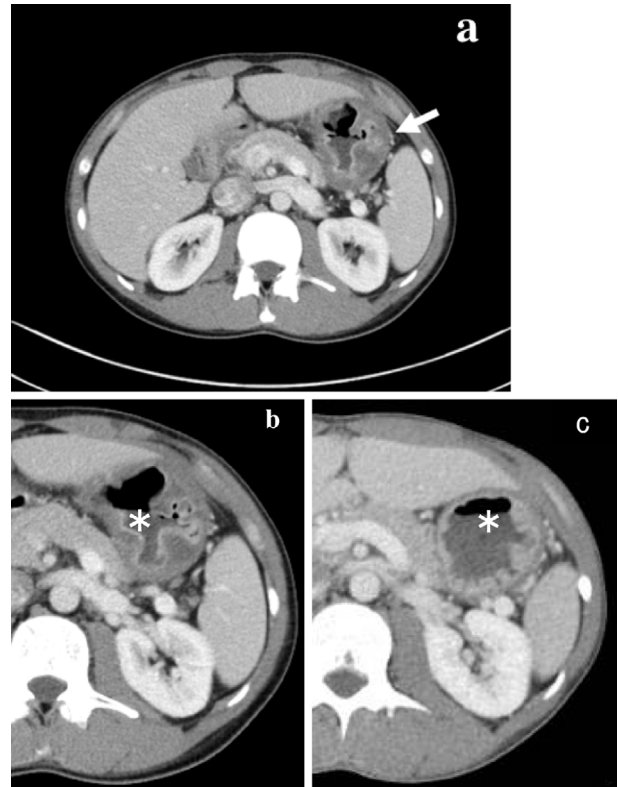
Axial contrast-enhanced CT image. (a, b) The gastric wall was diffuse and thickened on admission (arrow, asterisk). (c) Follow-up CT at 13 months showed that the diffuse thickness of the gastric wall had decreased compared with the same lesion on admission (asterisks in b and c)
